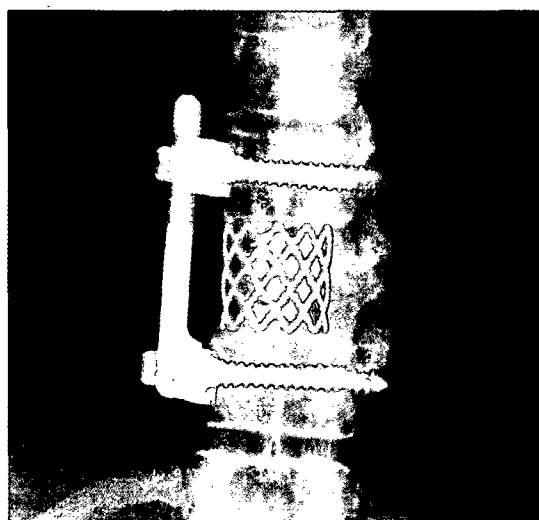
Radiography of an implant that was inserted after tumour resection in order to reconstruct the affected bony structure of the ninth thoracic vertebral body.*
